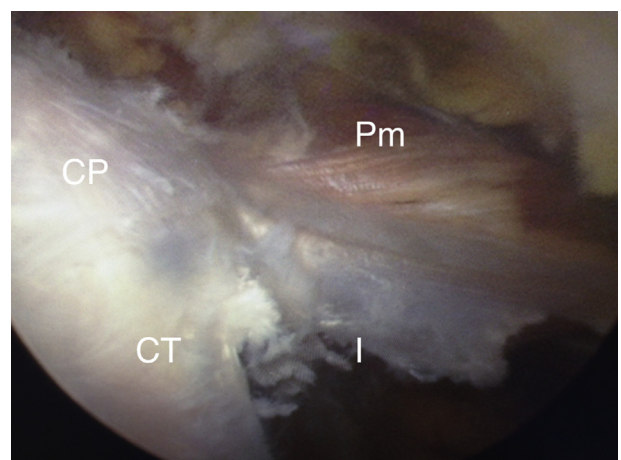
Extra-articular view of right shoulder in beach-chair position through anterolateral portal. The interval (I) between the pectoralis minor (Pm) and conjoint tendon (CT) is shown. (CP, coracoid process.)
